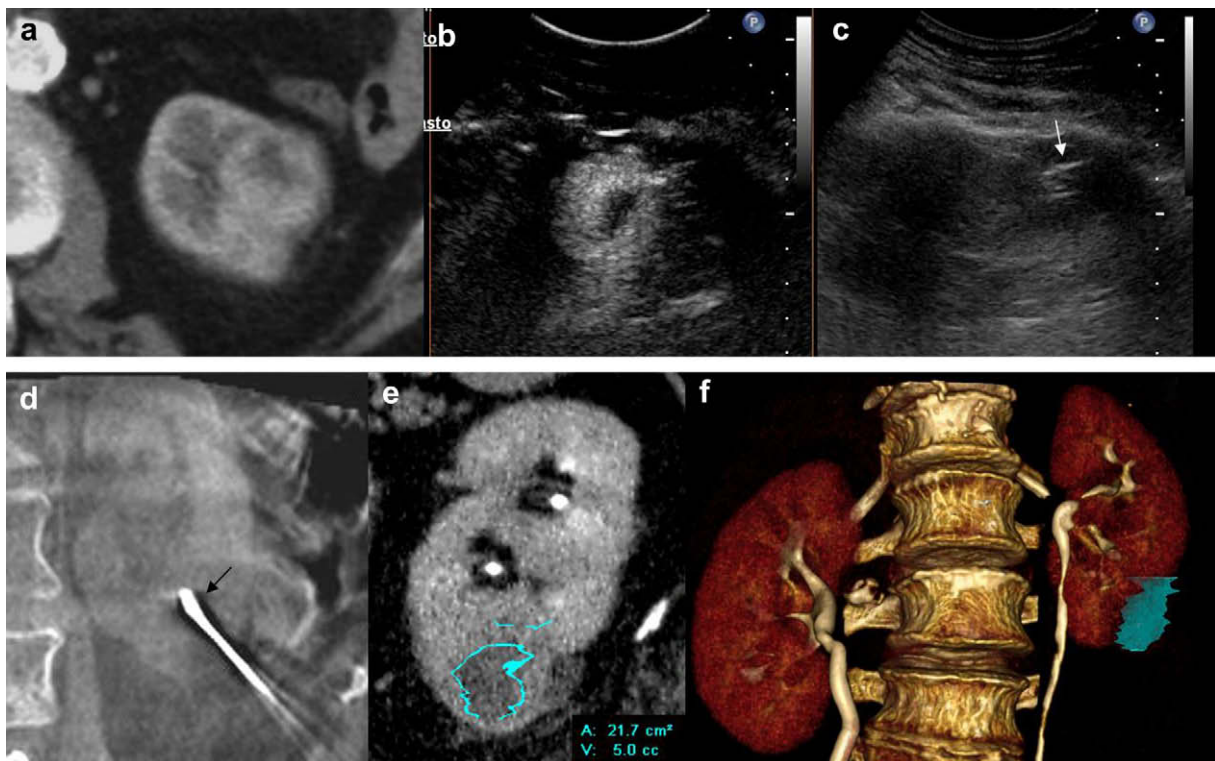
Microwave ablation of a primitive renal tumor. Pre-procedural CT (a). The procedure was performed with contrast-enhanced US (b-c) and C-arm cone-beam CT (d); antenna inside the lesions is well visible (arrows). CT performed 1 months after the procedure with calculation of ablation volume (e-f).
